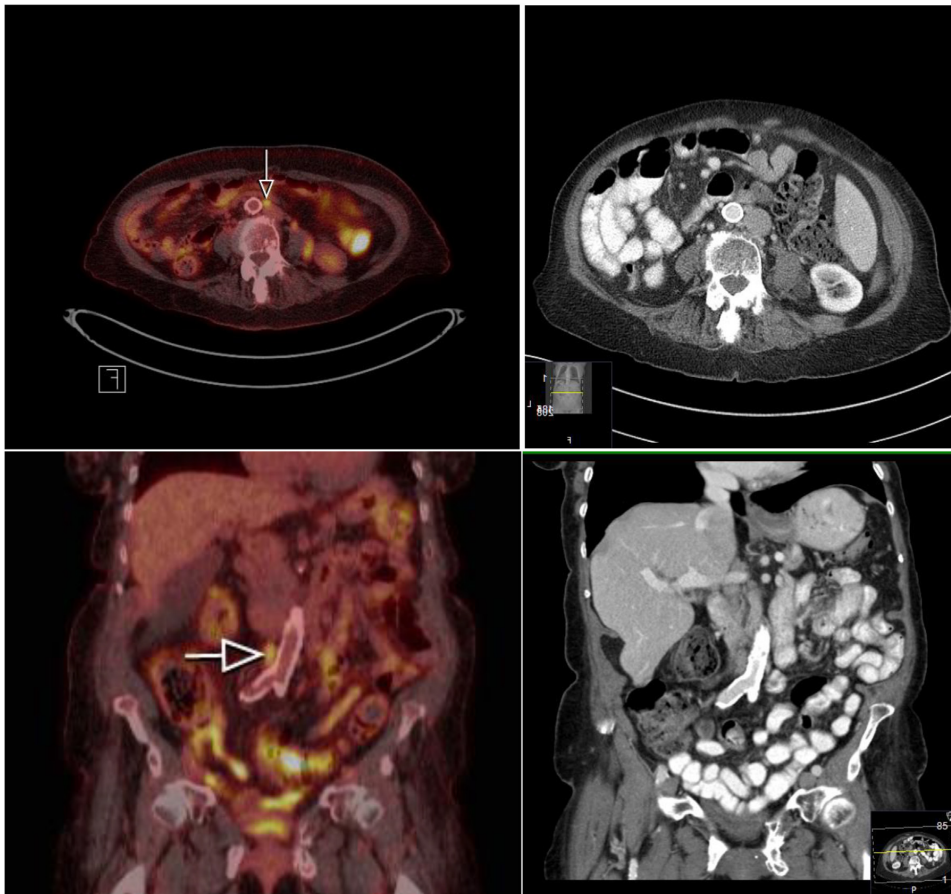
PET/CT images (left) showing metastatic paraaortic lymph node overseen on CT (right). The pictures are published with the patient’s consent.
